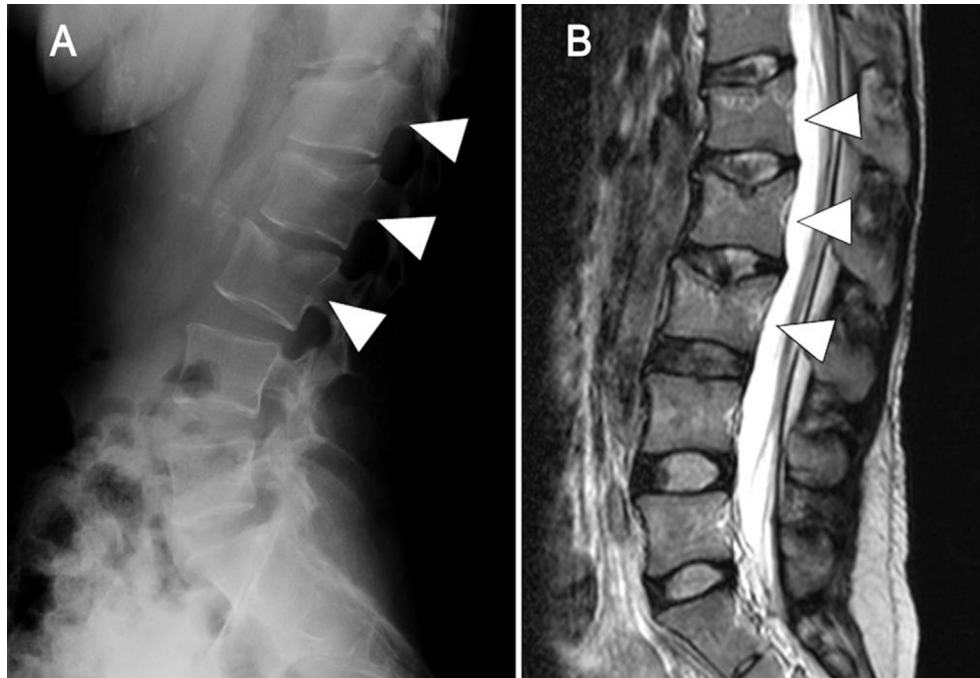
A: X-ray image of the spine; B: T2-weighted magnetic resonance image. Multiple vertebral fractures were detected at L1, L2, and L3.
